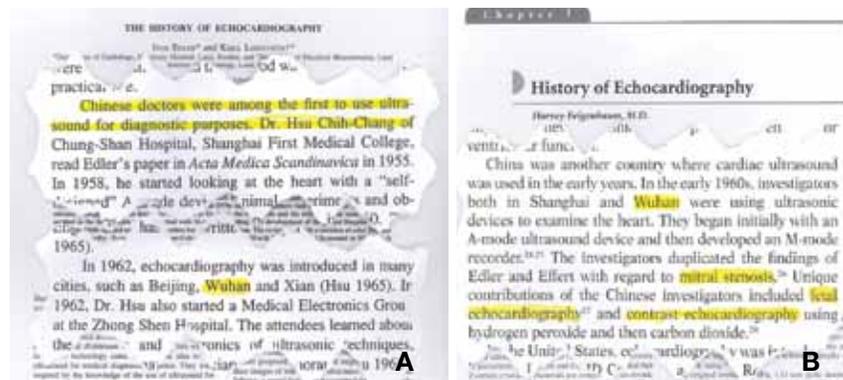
China’s early contribution to echocardiography from Shanghai and Wuhan (where Wang is) acknowledged by both (A) Edler⁷ and (B) Feigenbaum.⁸
